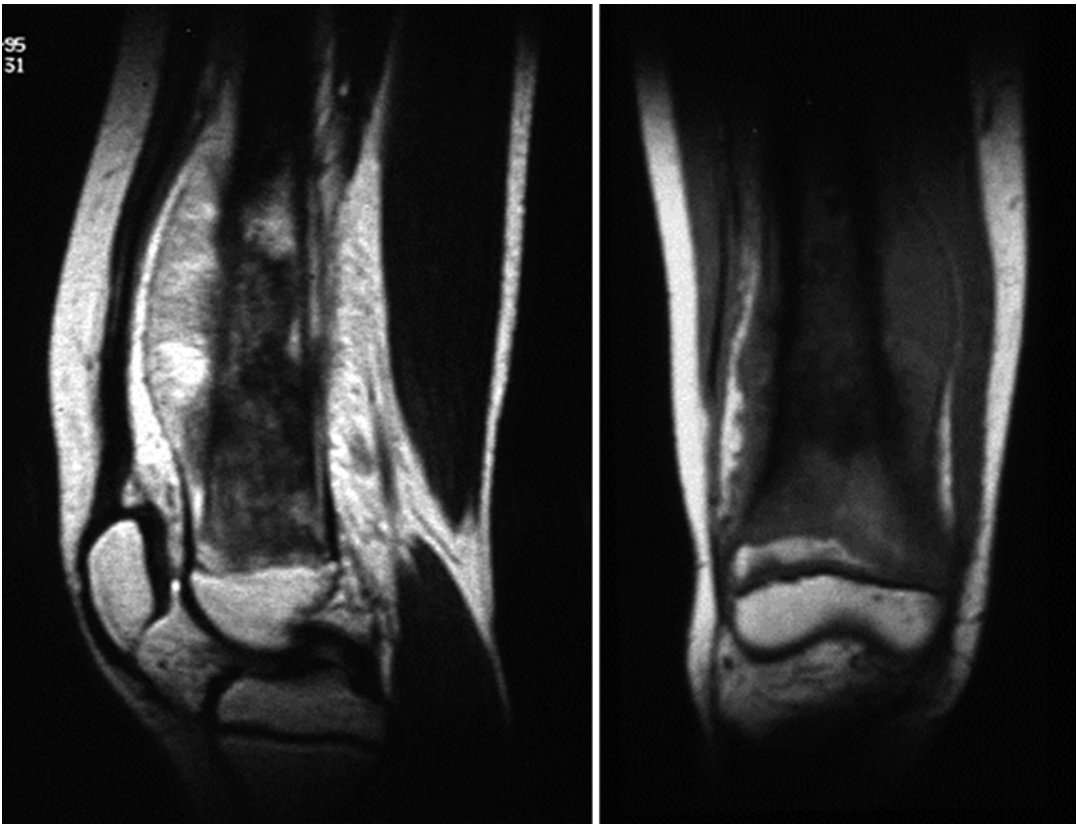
MRI showing the soft tissue and osseous components of a distal femoral osteosarcoma
